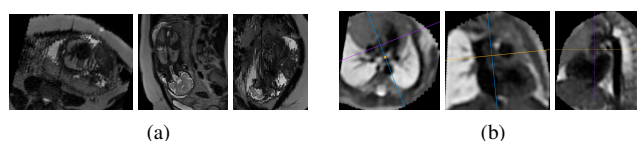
Multi-planar reconstruction of a multi-slice single-shot fast spin echo (ssFSE) MRI stack in a normal fetus (a). The reconstructed planes orthogonal to the acquisition plane show the extent of fetal movement between slices. Following the application of PVR to multiple overlapping stacks of 2D images, a fully navigable 3D volume of the fetal thorax shows clinically relevant cutting planes (b), providing detailed views of the extracardiac vasculature.
